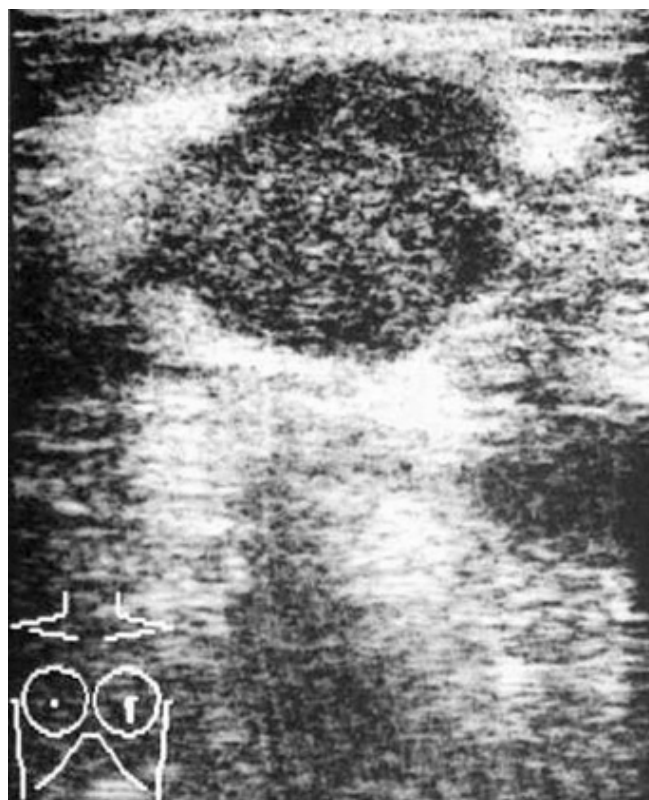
Ultrasound shows a hypoechoic lobulated mass without posterior shadowing.
